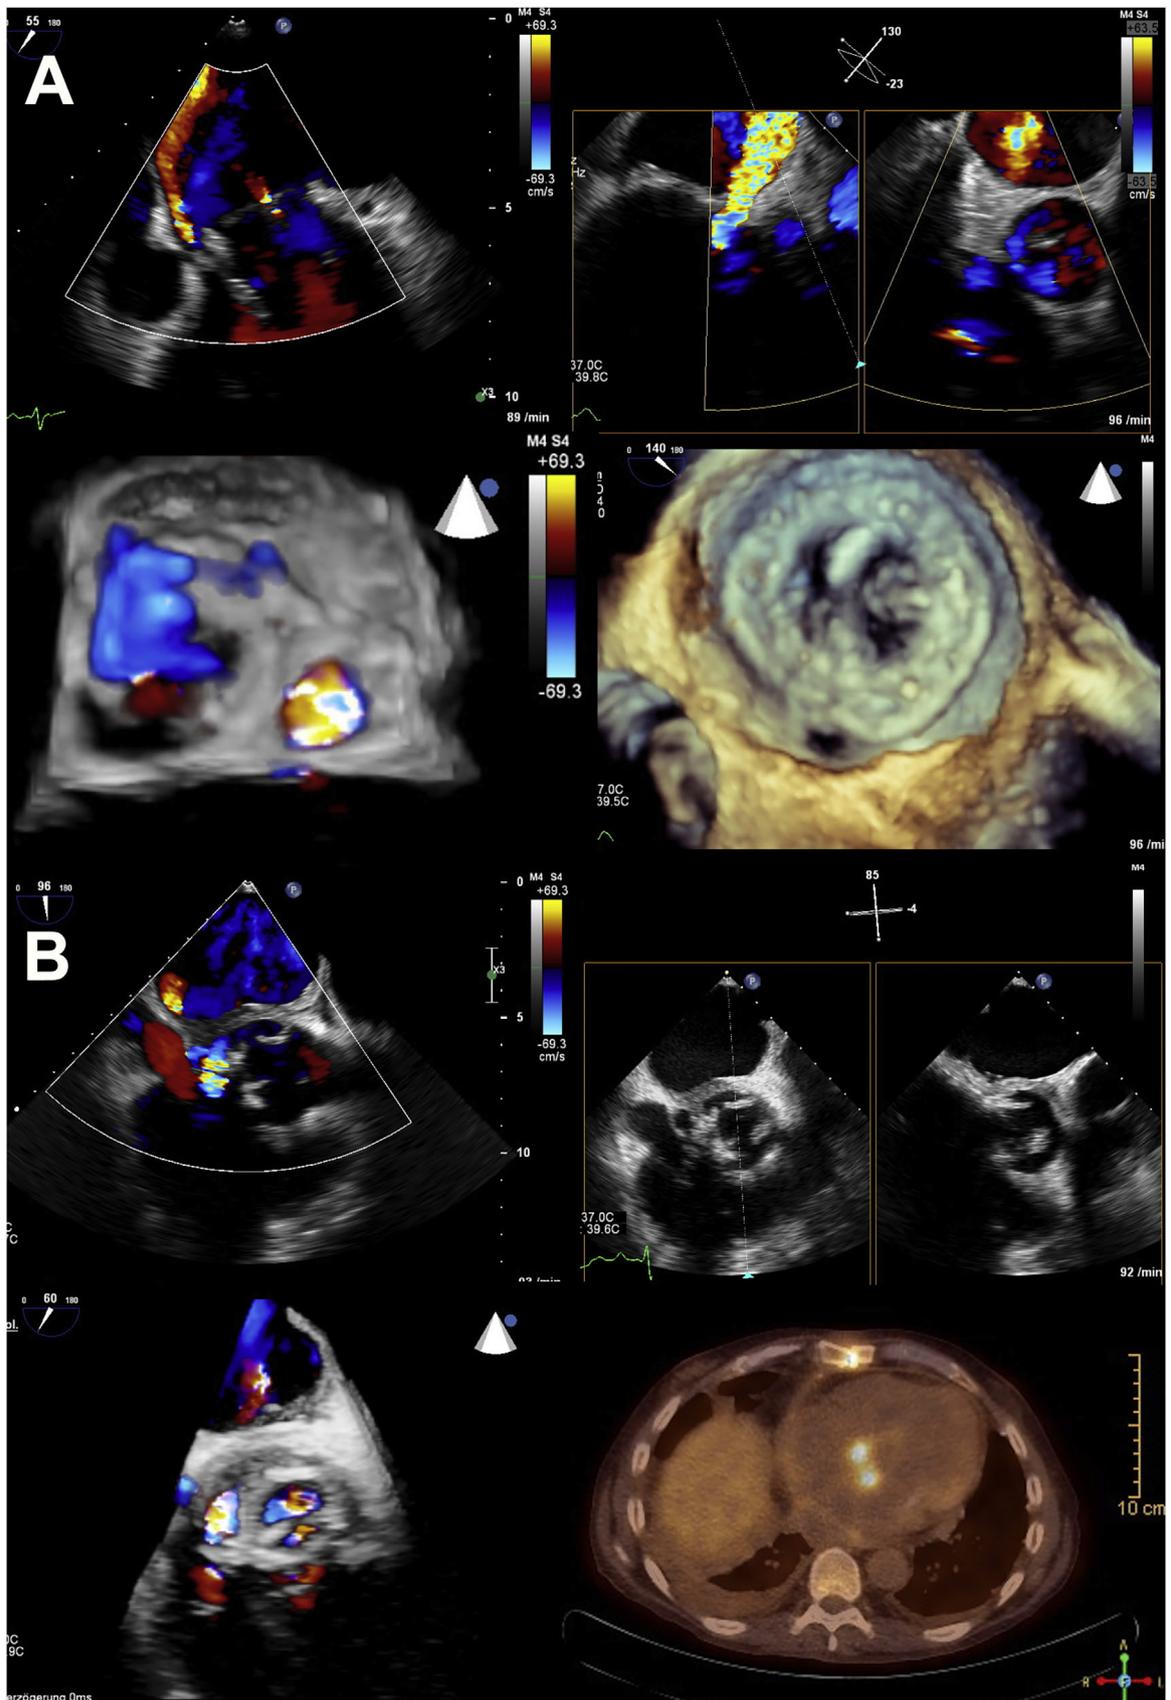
Prosthetic valve endocarditis of biological aortic and mitral valve. (A) Paravalvular mitral leakage in 2D transesophageal echocardiography (first row) and 3D transesophageal echocardiography (second row). (B) Paravalvular aortic leakage and dehiscence (first row) and 3D paravalvular jet and positron emission tomography/computed tomography (second row).
